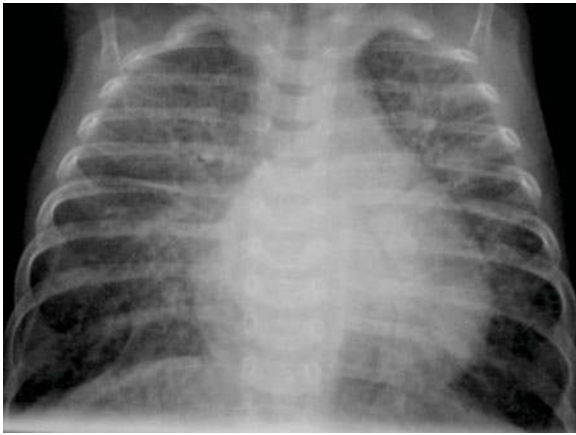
A 4-month-old girl with cor triatriatum. Chest radiograph shows marked bilateral pulmonary venous congestion
